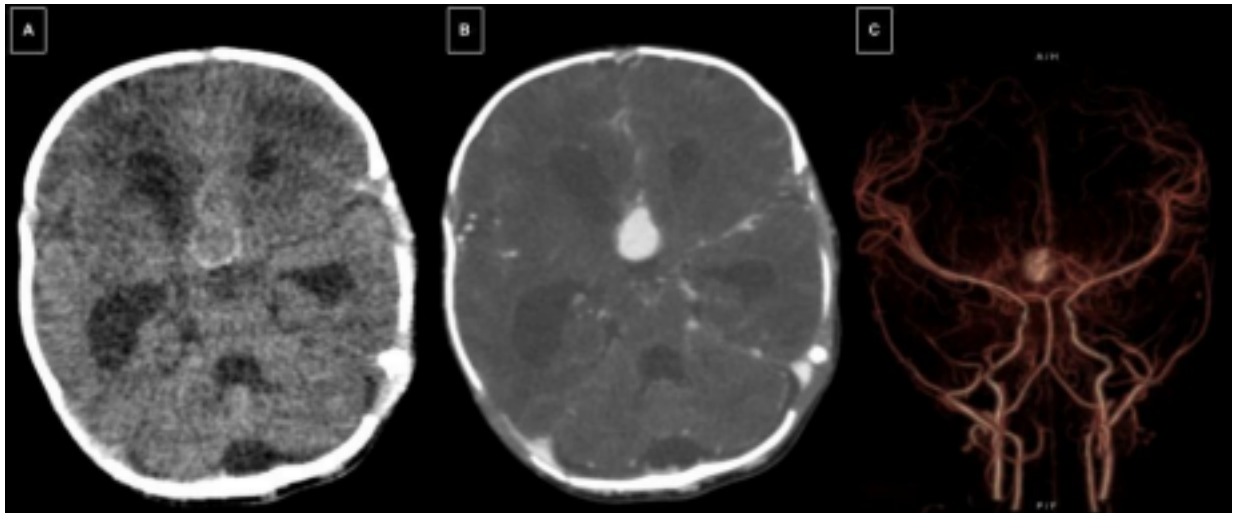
CTA. A) Noncontrast axial image. It is observed an hypodense nodule in anterior arterial topography, between A1 and A2 segments, a finding that suggests an aneurysm. B) The same plane with contrast shows that the nodule enhances and presents an irregular rounded shape. C) 3D reconstruction CT. Left anterior cerebral artery saccular aneurysm is confirmed.
